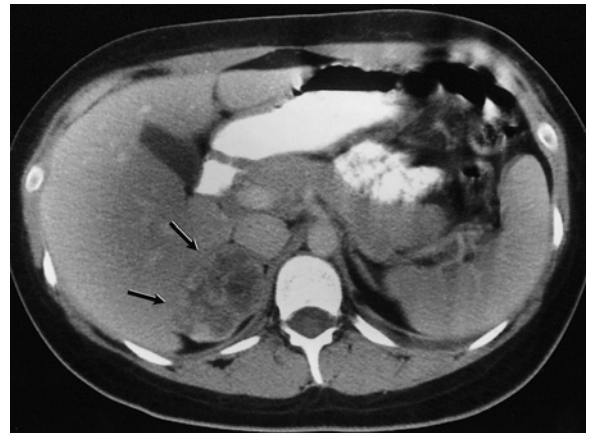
Magnetic resonance imaging identifying a right-sided aldosteronoma. (From Harrington et al. [5]. Reprinted with permission of Springer-Verlag)
